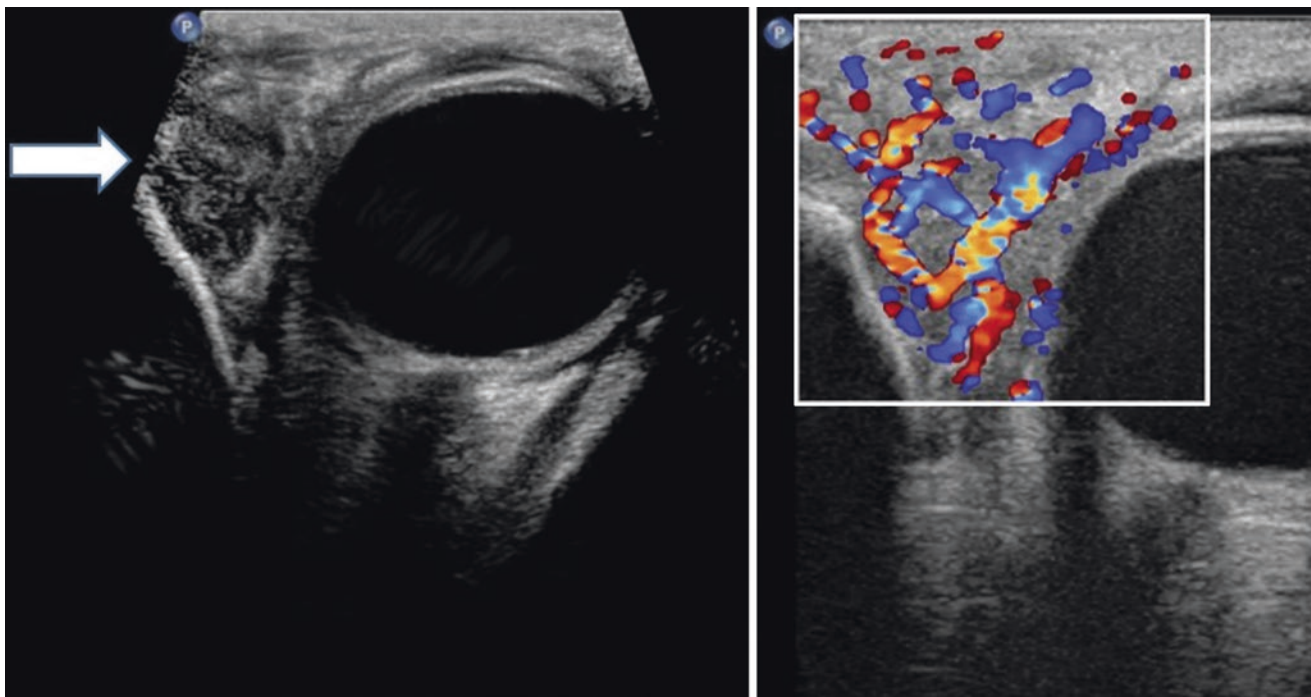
Targeted ultrasound scans of the left orbit showing a slightly lobulated and heterogeneous and hypoechoic solid extraconal mass in the medial aspect of the left orbit (white arrow). Prominent internal mixed arterial and venous flow is demonstrated within the mass in the picture on the right
